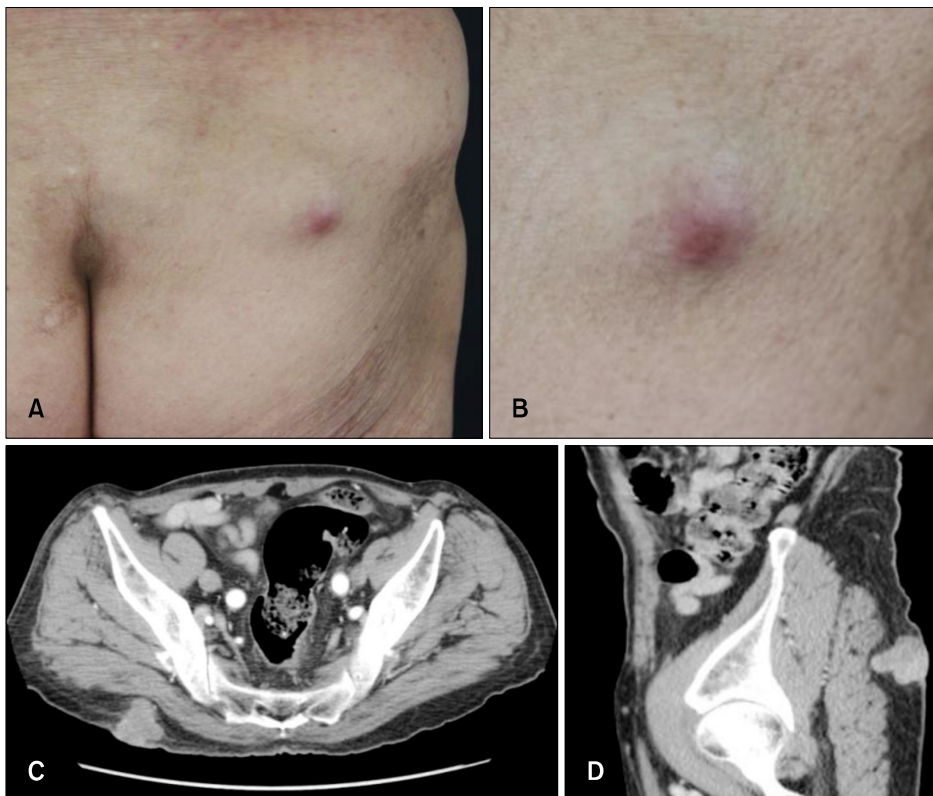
(A) A solitary hard deep seated nodule in the right buttock. (B) Close-up of the nodule in (A). Axial (C) and sagittal (D) computed tomography images showing a 3×4 cm irregularly shaped metastatic soft tissue mass in the subcutaneous layer of the right buttock.
